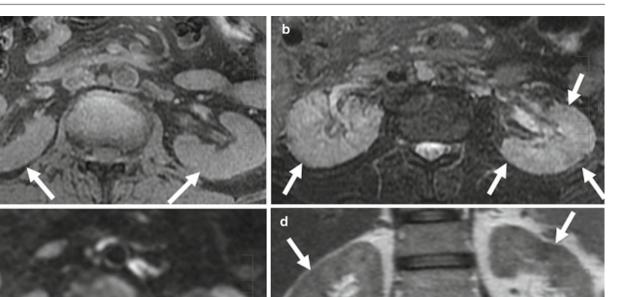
On T1-weighted images, (a) the hyperintensity of the normal cortex has disappeared. On T2-weighted images, (b, d) lesions are depicted as hypointense areas. On diffusion-weighted images, (c) lesions are hyperintense (a–d *arrows*)
